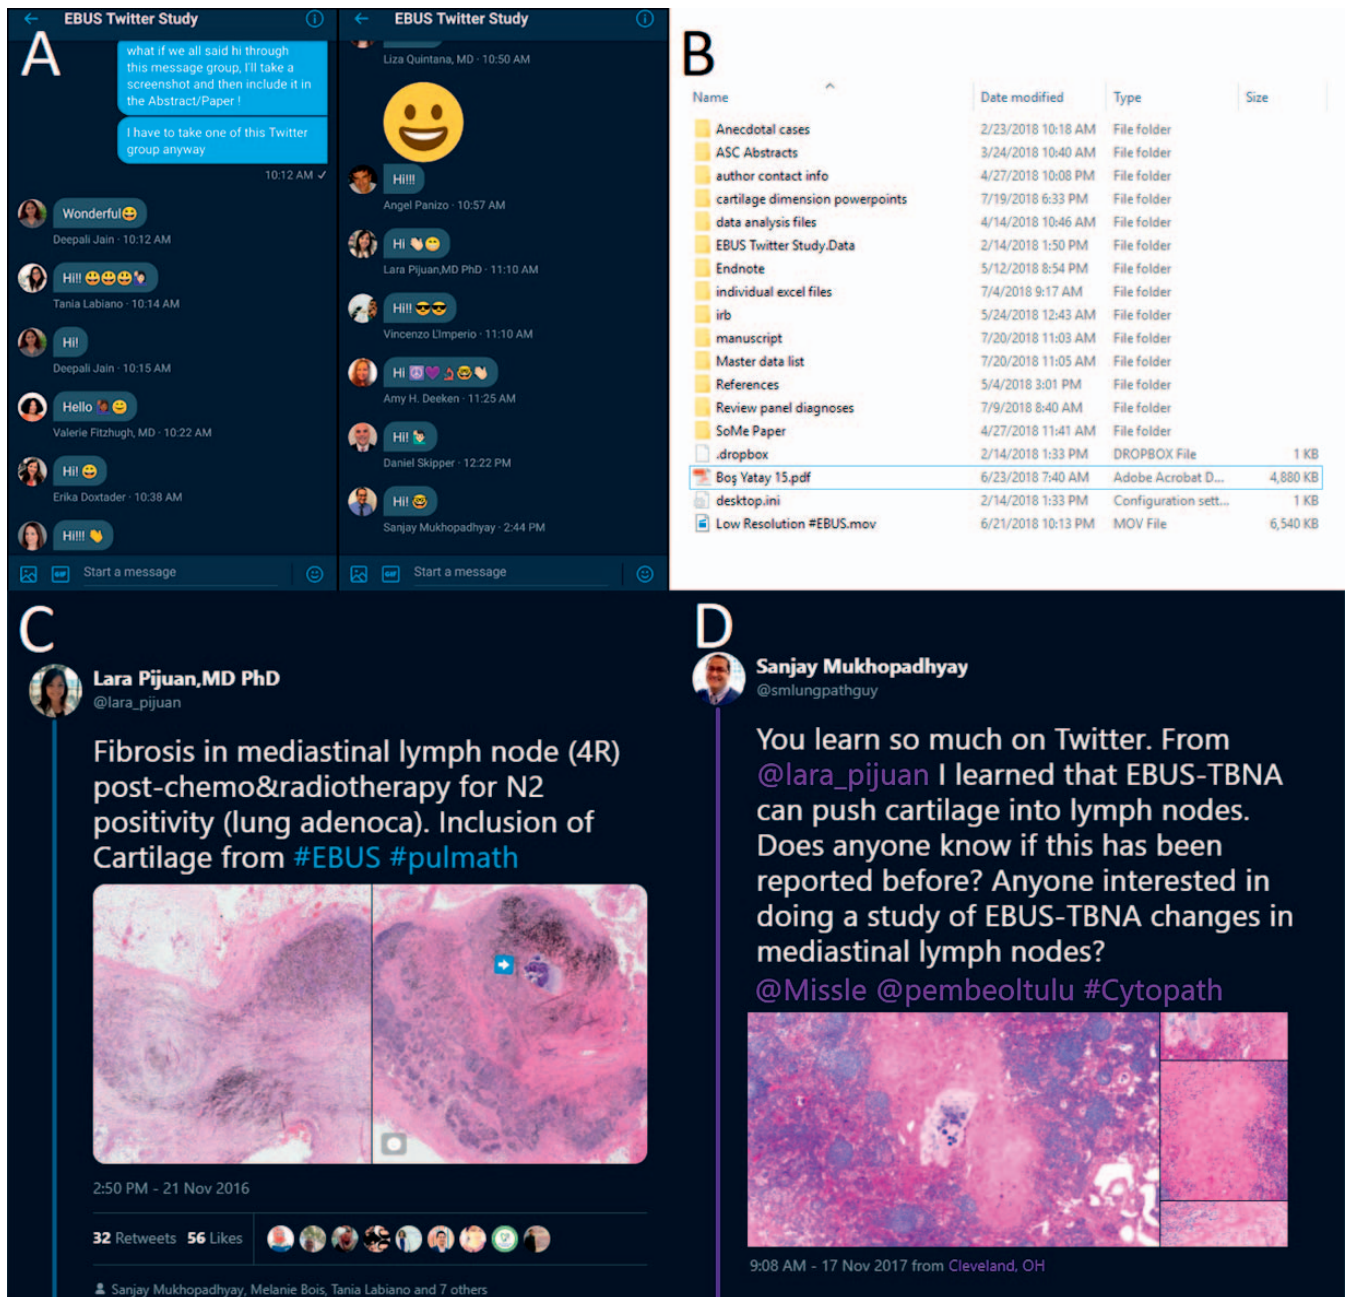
A, Dedicated #EBUSTwitter messaging group. B, Screenshot of the private folder hosted on the cloud service Dropbox. C, Dr Pijuan's initial tweet about her case: post-endobronchial ultrasound (EBUS) cartilage found within a sampled lymph node. D, Dr Mukhopadhyay's tweet a year after that sparked our interest in starting #EBUSTwitter.
